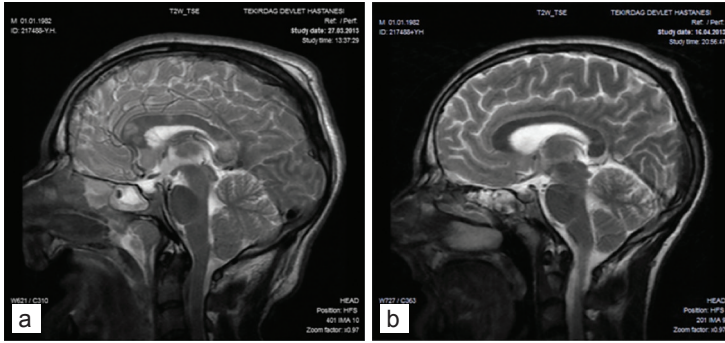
Contrast-enhanced diffusion-weighted magnetic resonance imaging (MRI) of the brain before (a) and after (b) the treatment
